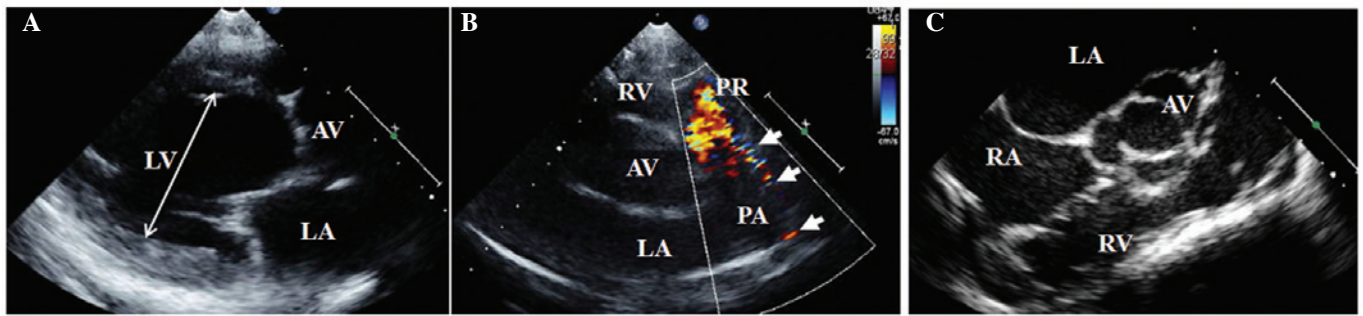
Echocardiography performed at the time of diagnosis. (A) Parasternal long axis view demonstrating a dilated left ventricle (double-headed arrow); (B) parasternal right ventricular outflow view demonstrating left to right flow (arrows) from the descending aorta to the pulmonary artery through the PDA; and (C) transesophageal echocardiography demonstrating the bicuspid aortic valve. PDA, patent ductus arteriosus; LV, left ventricle; LA, left atrium; RA, right atrium; AV, (bicuspid) aortic valve; RV, right ventricle; PA, pulmonary artery; PR, pulmonary regurgitation.
